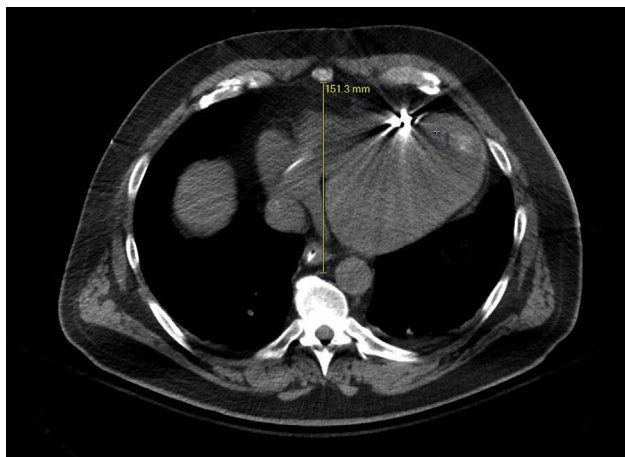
Thoracic diameter: The anteroposterior dimension on an axial computed tomographic image, measured from the posterior sternum to the anterior 10th vertebral body, should be >10 cm.
